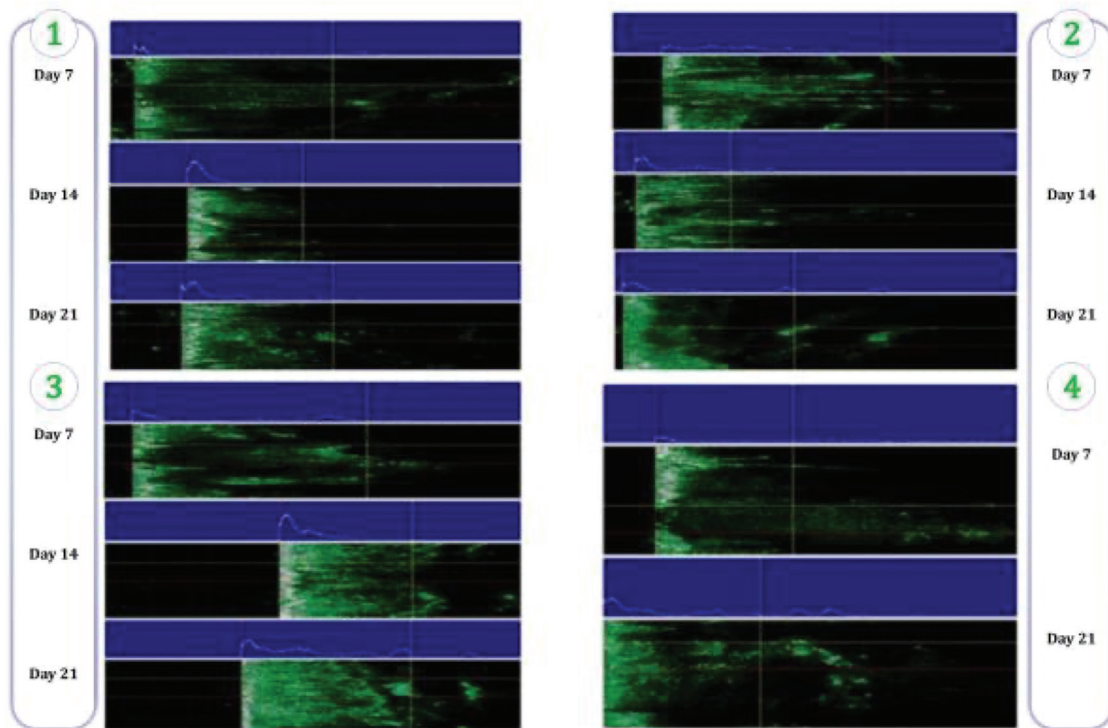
Ultrasound imaging for measurement of the density and thickness of the wound area skin using a 75 MHz ultrasound probe on the days 7, 14, and 21 after the treatment
